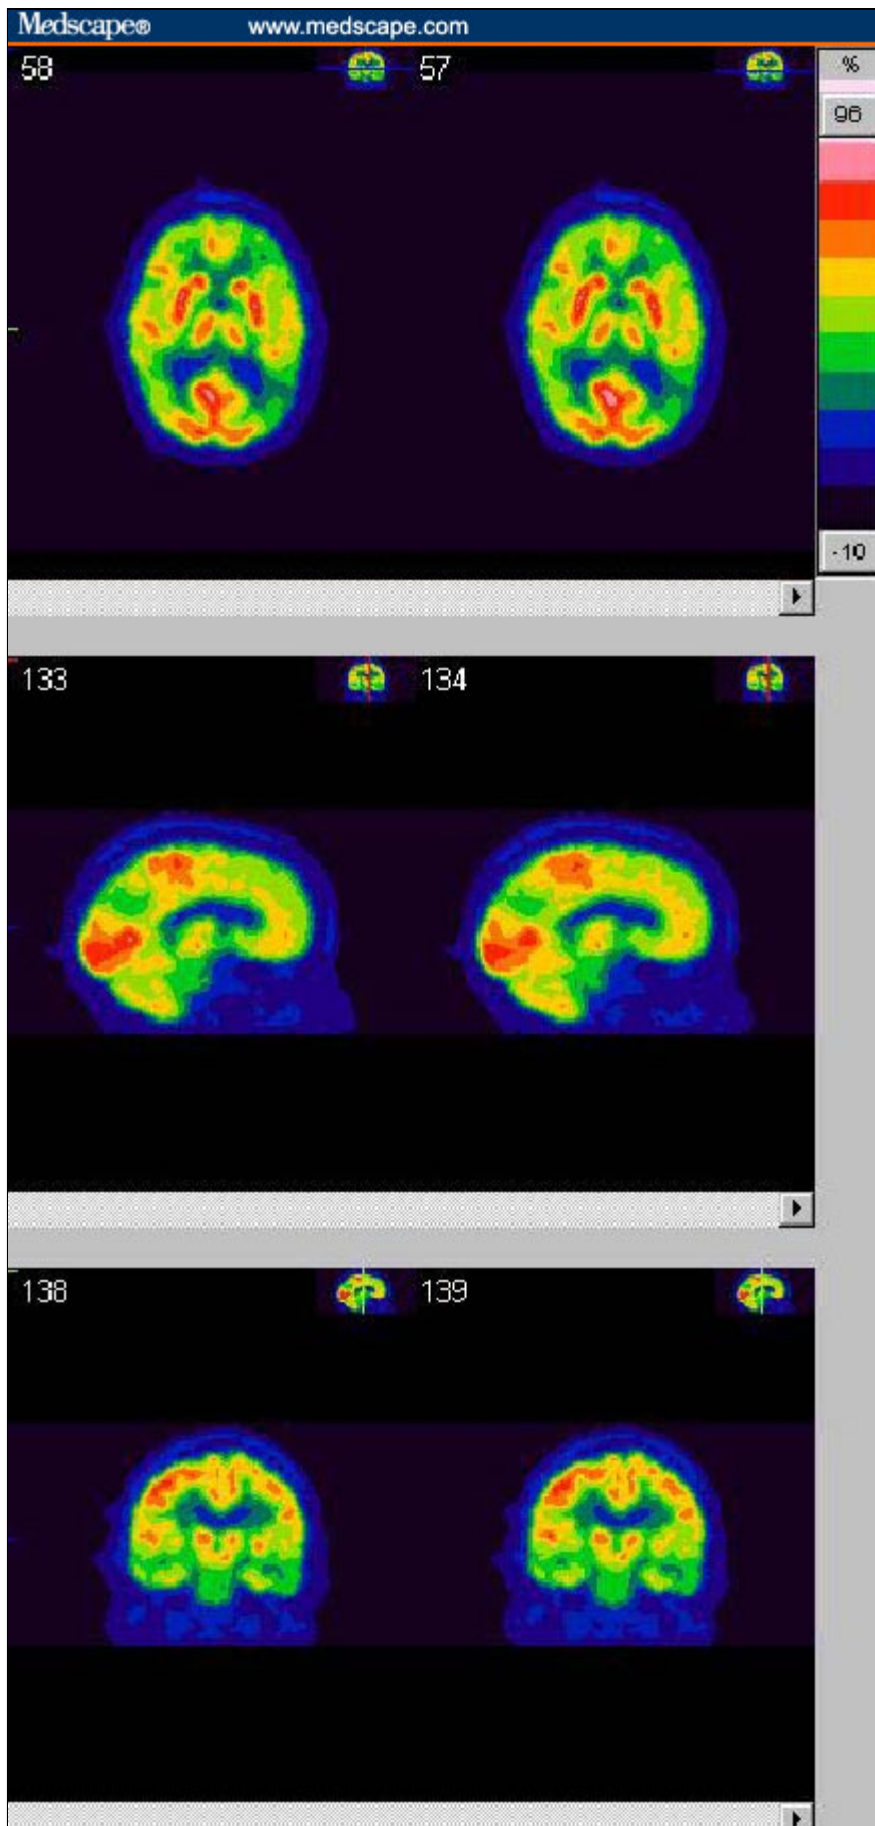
Coronal (top), sagittal (middle), and axial (bottom) FDG PET images of a patient with Alzheimer's disease. Note the marked relatively symmetric bilateral temporoparietal hypometabolism with sparing of the visual cortex, sensorimotor strip, and the subcortical grey matter.
